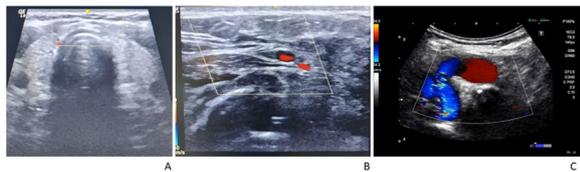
(abstract 001316) Examples of ultrasound (US) prior to percutaneous tracheostomy (PT). A: Neck US suitable for standard PT technique. B: Neck US suitable for PT with precaution. C: Neck US contraindicates PT.
